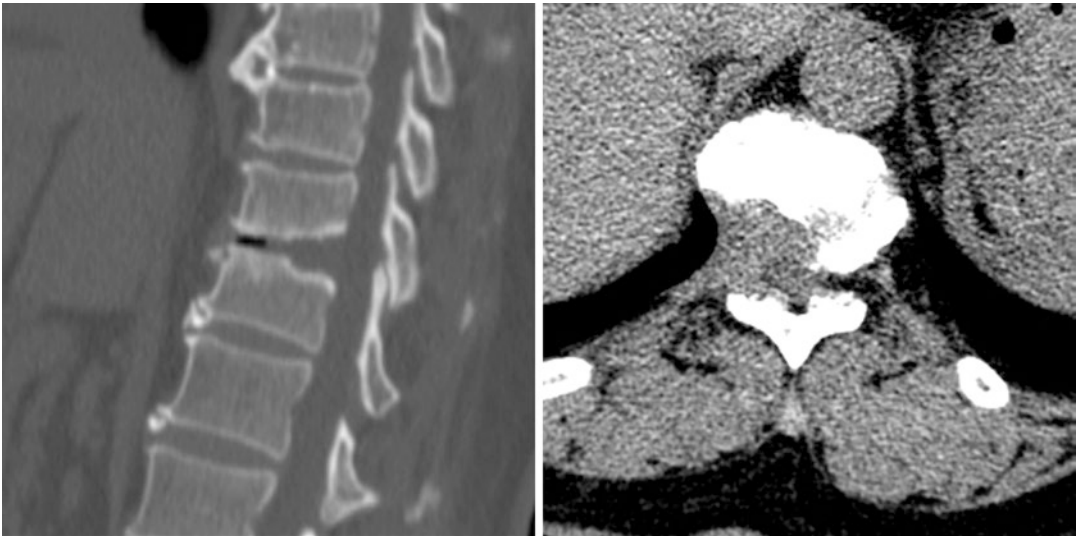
Postoperative CT images were taken 6 months later
